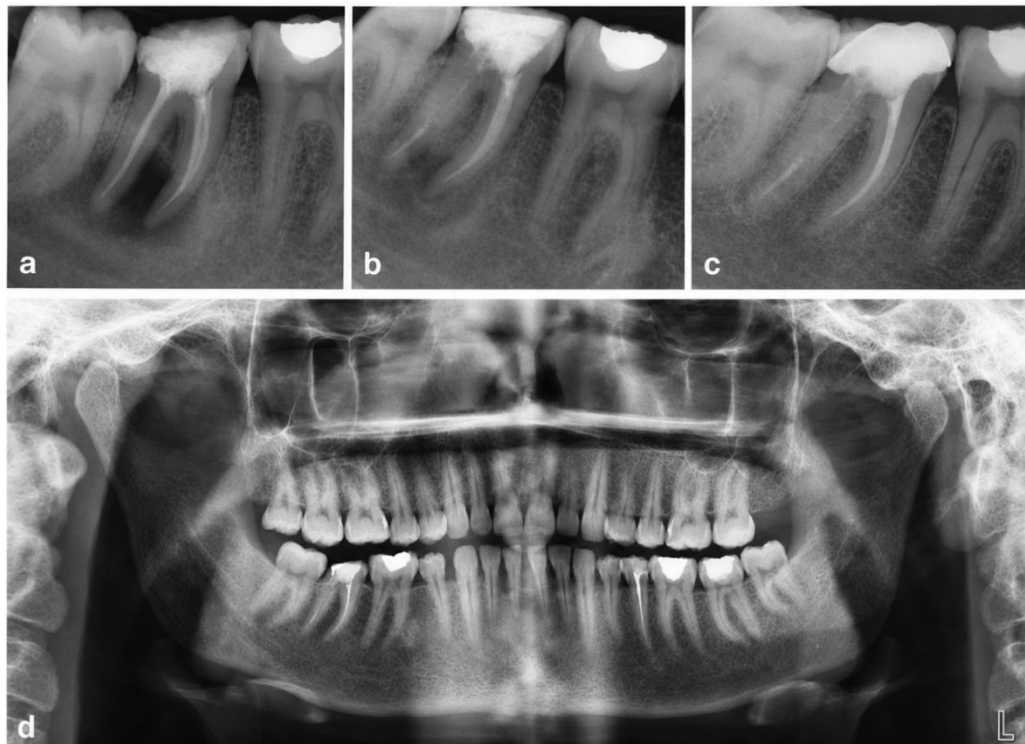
Radiographic follow-up findings after endodontic treatment. (a) Periapical radiograph obtained after completion of root canal obturation. (b) Three-month follow-up radiograph showing early signs of periapical healing. (c) Twelve-month follow-up periapical radiograph showing marked regression of the periapical radiolucency and osseous healing. (d) Panoramic radiograph obtained at the 1-year follow-up.
